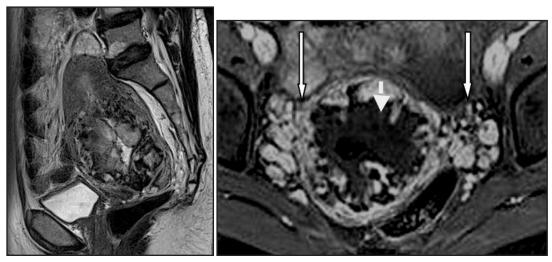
Sagittal T2-weighted (a) and axial T1-weighted post contrast (b) images of the pelvis demonstrate a mass of heterogeneous T2 signal with peripheral nodular enhancement and a central area of fluid signal, in keeping with necrosis (short white arrow). Distended serpiginous vessels (long white arrows) are seen around the uterine mass.
